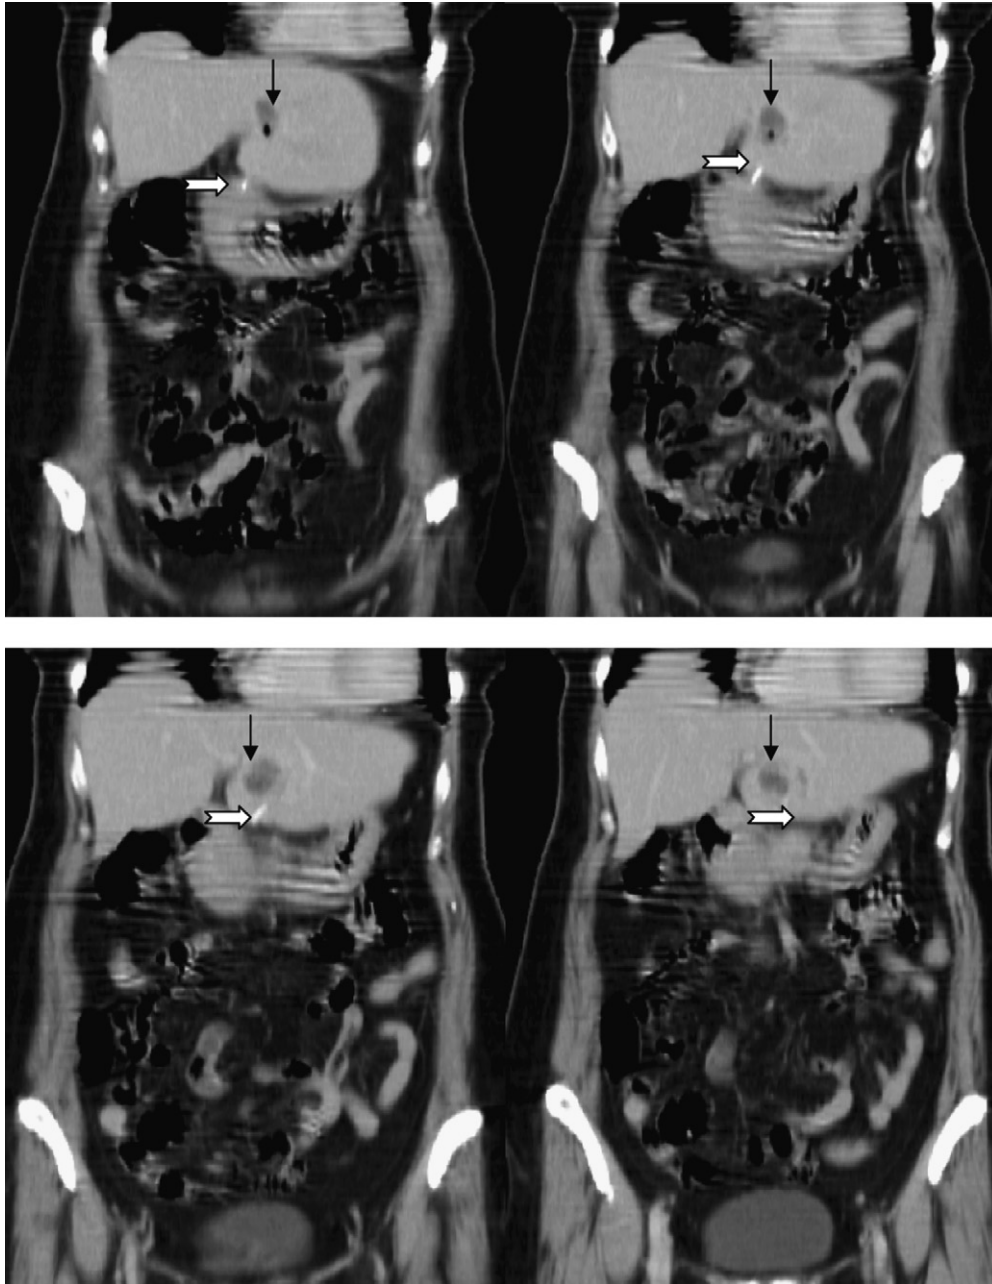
Contrast-enhanced CT image shows a heterogeneous lesion in the left lobe of the liver, consistent with liver abscess (black arrow). The white arrow indicates a fish bone extending from the gastric antrum to the liver parenchyma.
